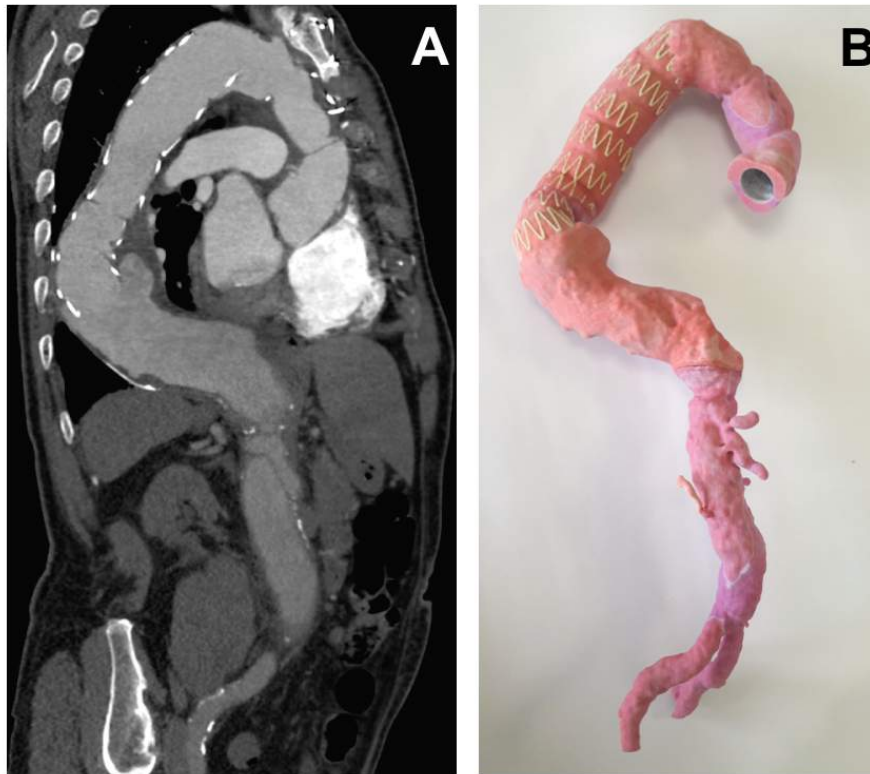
(A) 11-year follow-up CT scan is compared to (B) the 3D model showing distal neck degeneration and type IB endoleak.
